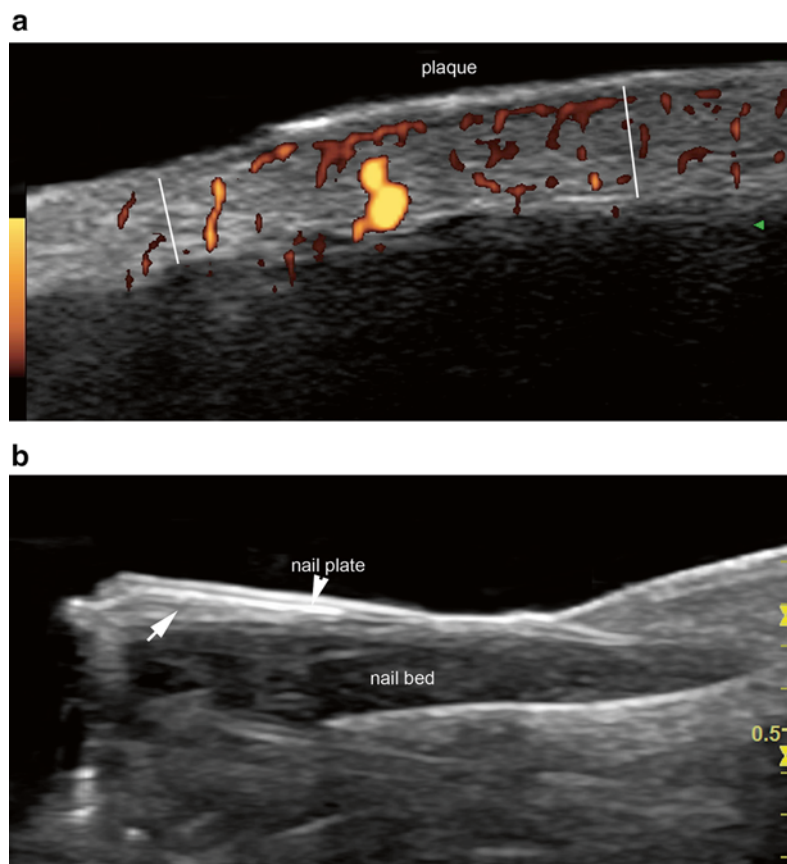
(a) (Top) Psoriasis. Cutaneous plaque shows epidermal and dermal thickening and increased regional blood flow on power Doppler. The vertical white lines are pointing out the normal (left aspect) and abnormal regions (right aspect). (b) (Bottom). Nail involvement demonstrates thickening of the ventral plate (arrow) and the nail bed
